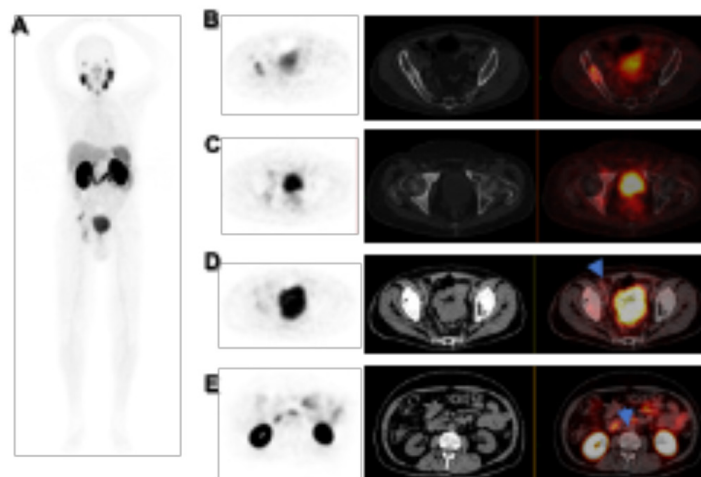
^{68}Ga -PSMA PET/CT restaging in 70-years-old patient with biochemically recurrent prostate cancer and rising level of prostate-specific antigen: PET maximum intensity projection (A), axial PET/CT shows blast involvement in the right hemipelvis with foci showing moderate PSMA expression (SUV_{max} : 4.6, score 2) (By C), lymph nodes with partial calcification at the level of the aortic bifurcation and in the right external iliac region that do not present PSMA expression, probably post-treatment changes (D), lymph nodes in the inter-aortocaval region (up to 10 mm short diameter) and para-aortics without PSMA expression, score 0 (E)
